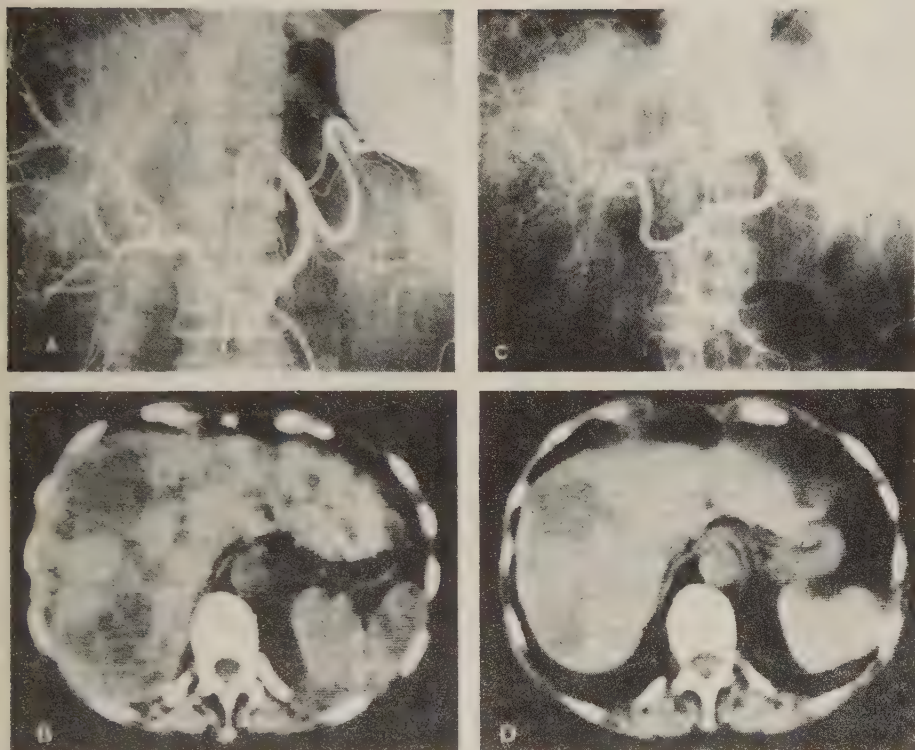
Coeliac angiography demonstrates an enlarged liver with intrahepatic arteries displaced by metastases. B. CT-examination the same day as angiography shows widespread metastases. C. Coeliac angiography one year after A shows reduced liver size. Intrahepatic arteries no longer displaced. D. CT-examination one day after C shows markedly reduced size of liver metastases in comparison to B.
